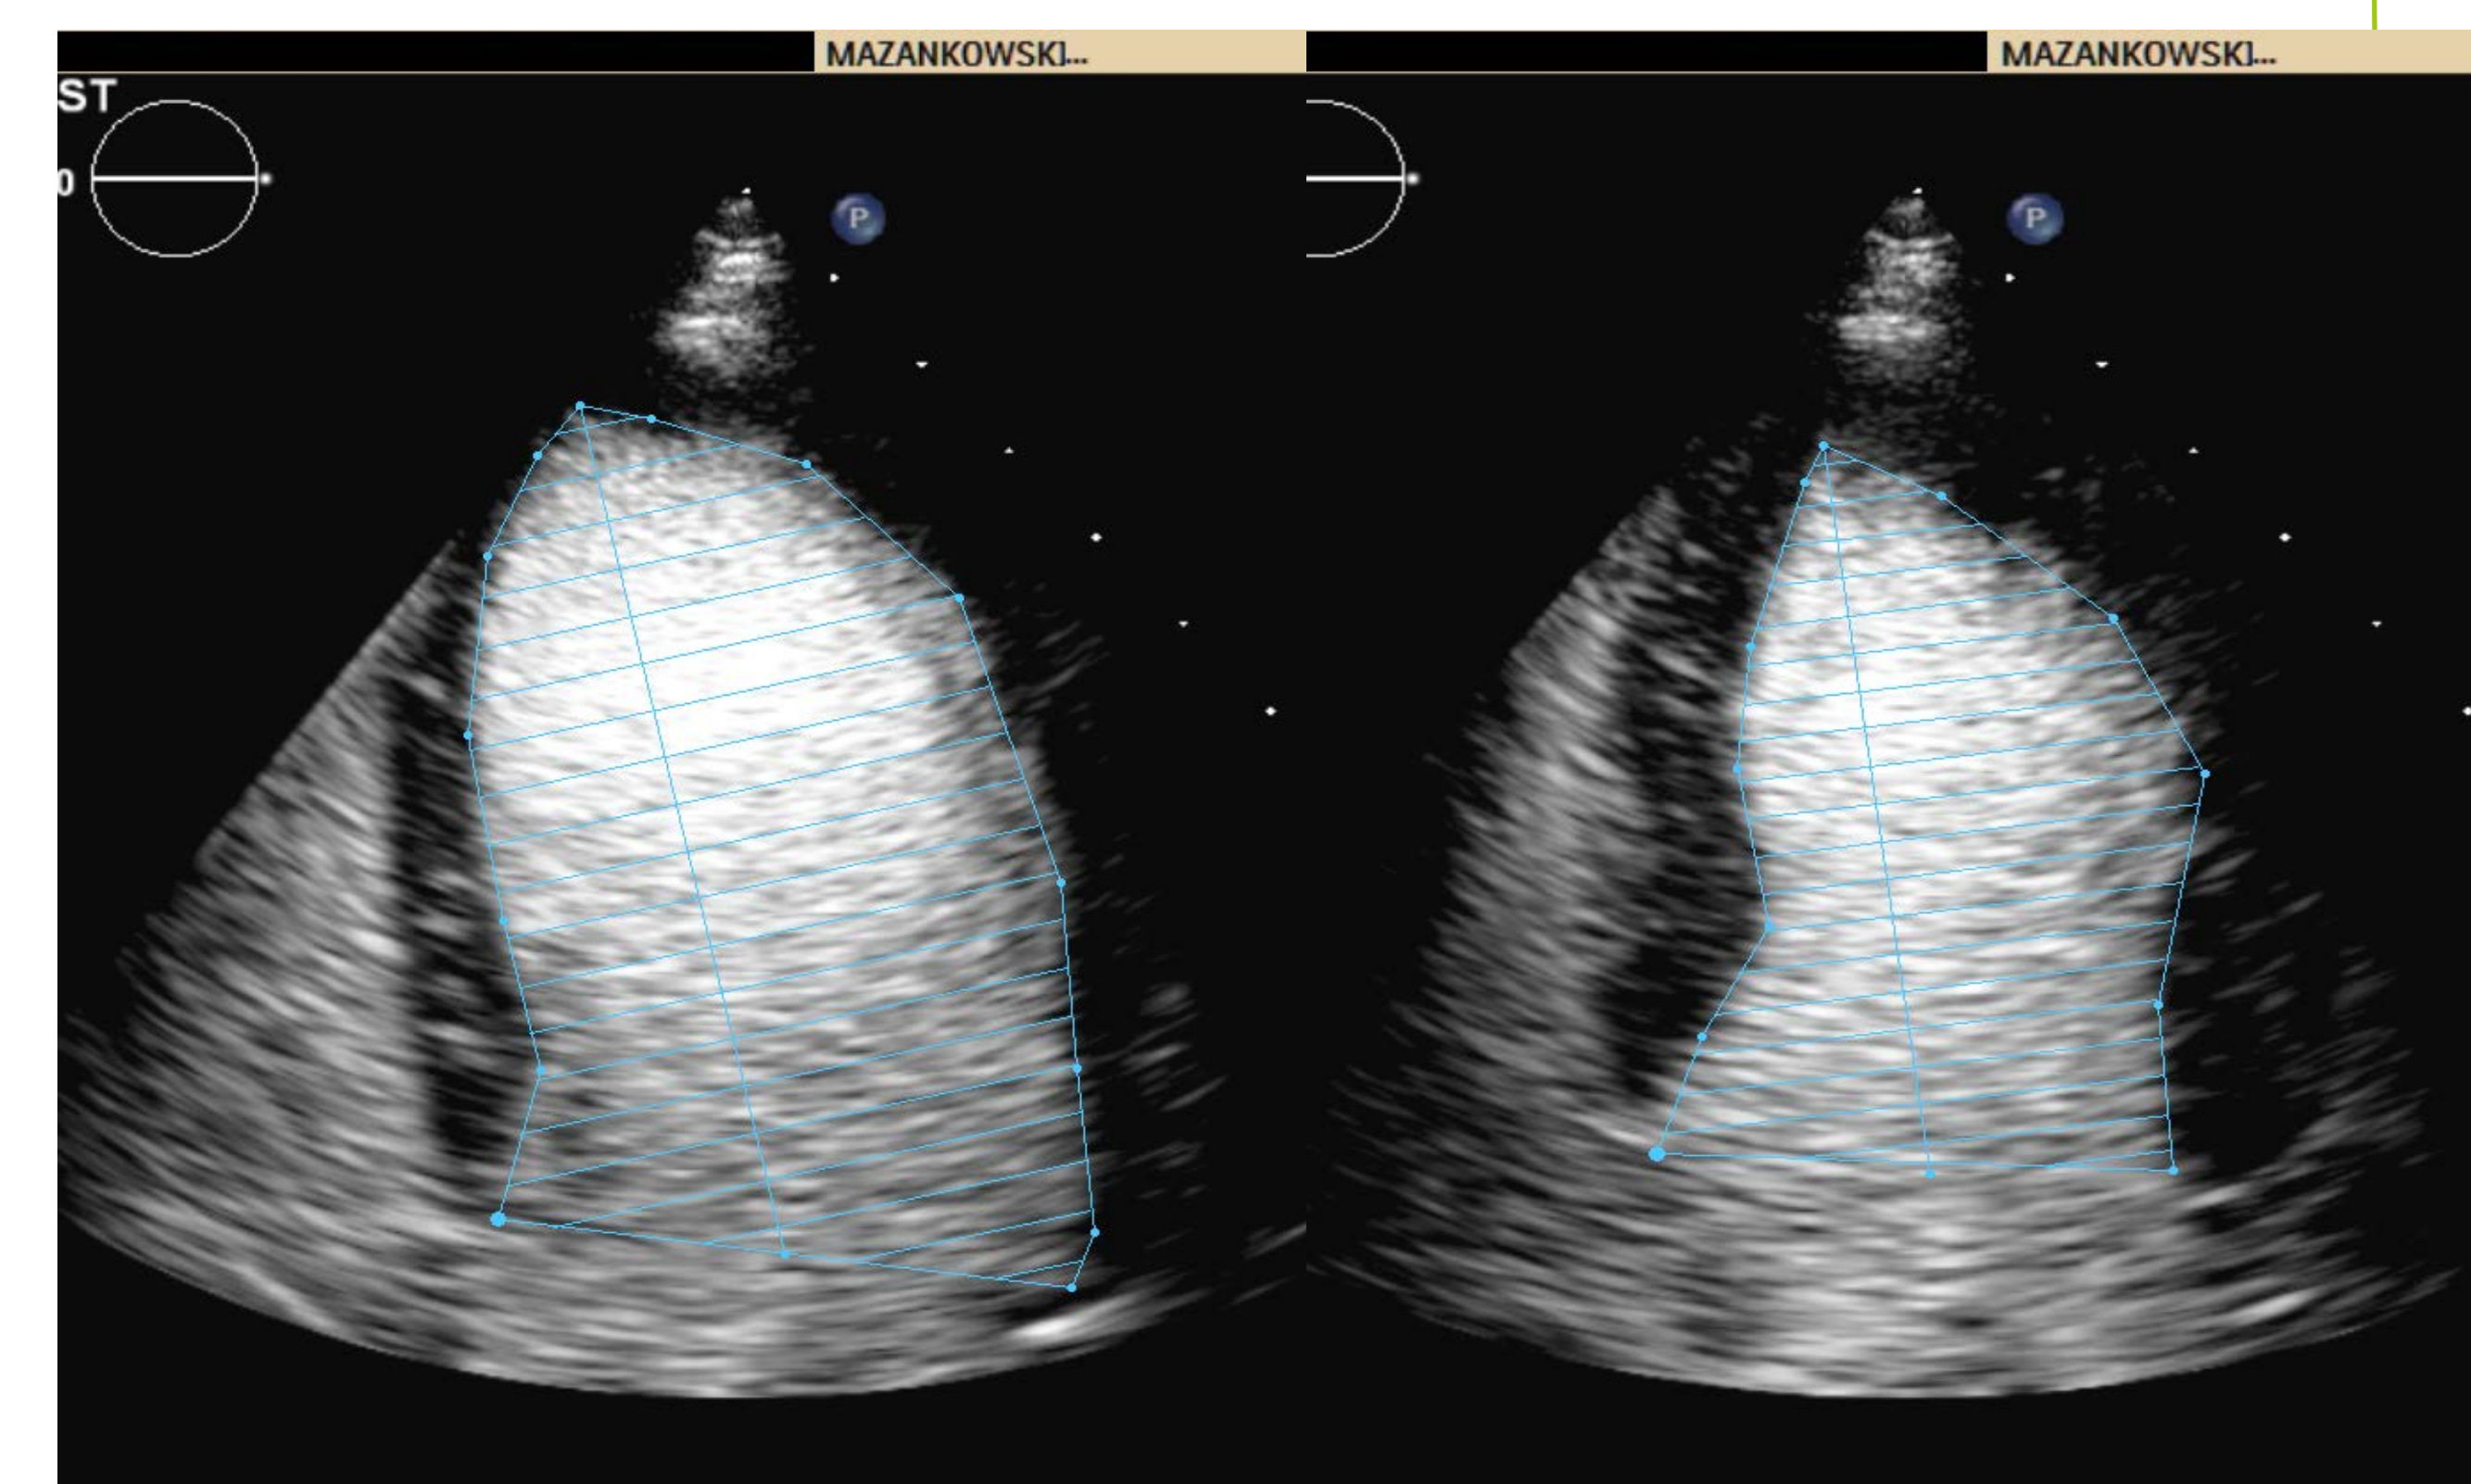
Apical 4Ch of CE-2DE in the end diastole and systole
